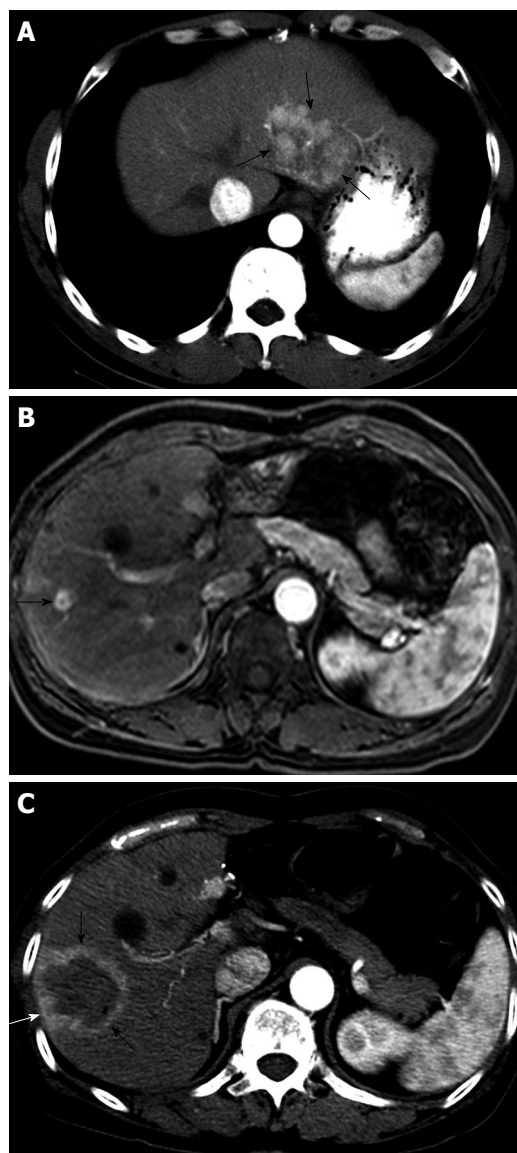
Successful RFA of intrahepatic recurrent HCC in a 49-year-old man. A: Contrast-enhanced transverse helical CT scan obtained during the arterial phase before hepatectomy shows a 5.7-cm-diameter HCC (arrows) in left lateral segment; B: At 5 years after left lateral segmentectomy, Gd-EOB-DTPA-enhanced T1-weighted MR image obtained during the arterial phase before RFA shows a 1.0-cm-diameter recurrent HCC (arrow) in liver segment 8; C: Contrast-enhanced transverse helical CT scan obtained 1 h after RFA shows a round ablation zone (arrows) of low attenuation with peripheral rim hyperemia. The patient has been alive without recurrence for 14 mo.
